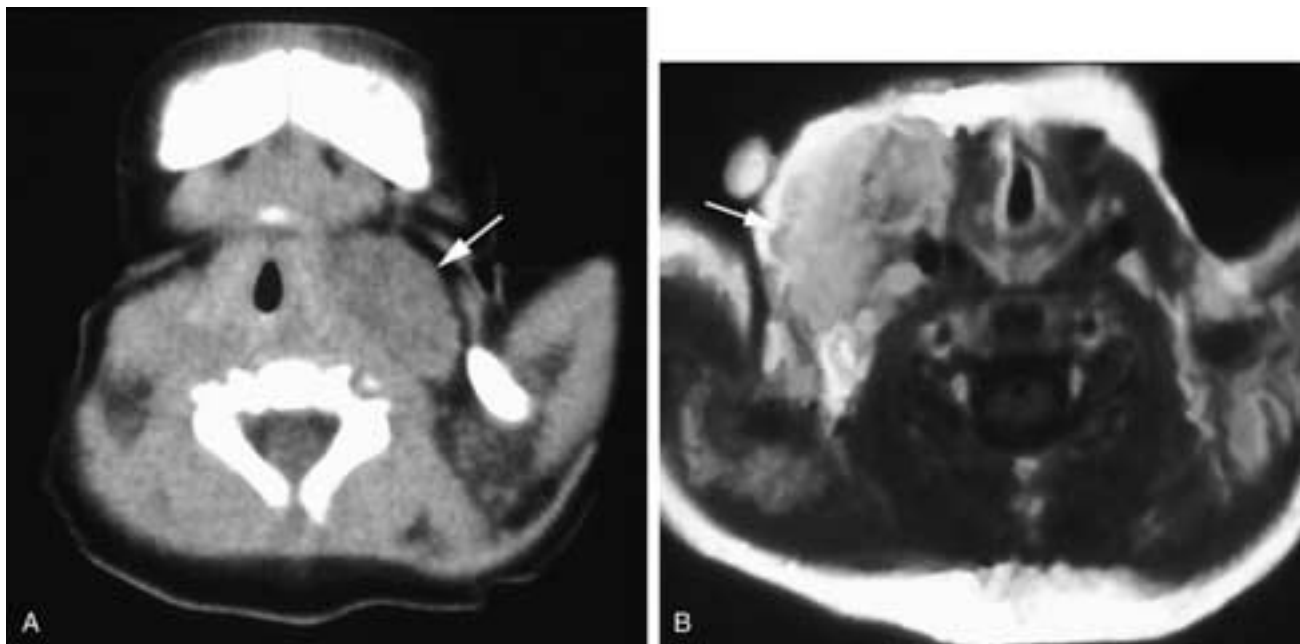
Axial CT scan (A) shows an enlarged left sternocleidomastoid muscle of slightly lower attenuation than that of normal muscle in this infant. Axial T1-weighted, contrast-enhanced MR image (B) on another patient shows enhancement of a grossly enlarged right sternocleidomastoid muscle (*arrow*). Both of these patients had fibromatosis colli. (Courtesy of Dr. Larissa Bilaniuk.)
